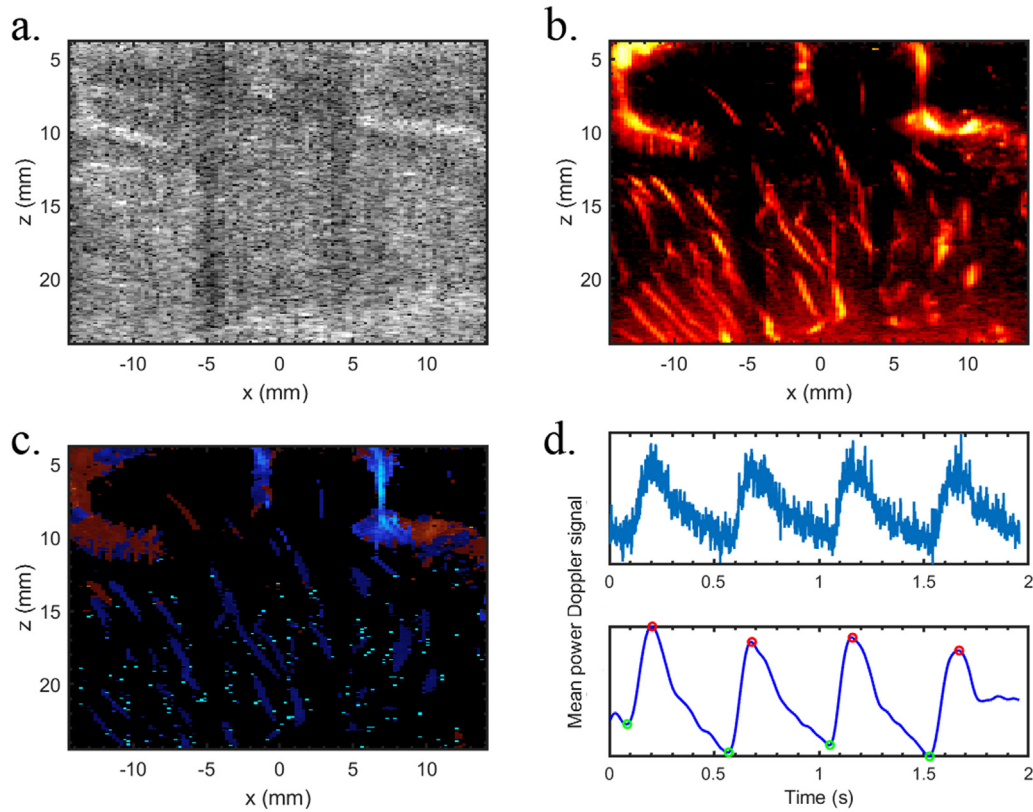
Data preparation steps. (a) The beamformed B-mode data. (b) Power Doppler data after smoothing and singular value decomposition filtering on the in-phase and quadrature data. (c) Directional power Doppler. *Red* indicates dominant flow toward the probe, and *blue*, away from the probe. (d) Slow-time high-pass filtered average time signal of all pixels, indicating the overall pulsatility (top). The timing of systolic peaks (*red dots*) and end-diastolic valleys (*green dots*) are added to the smoothed curve (bottom).
